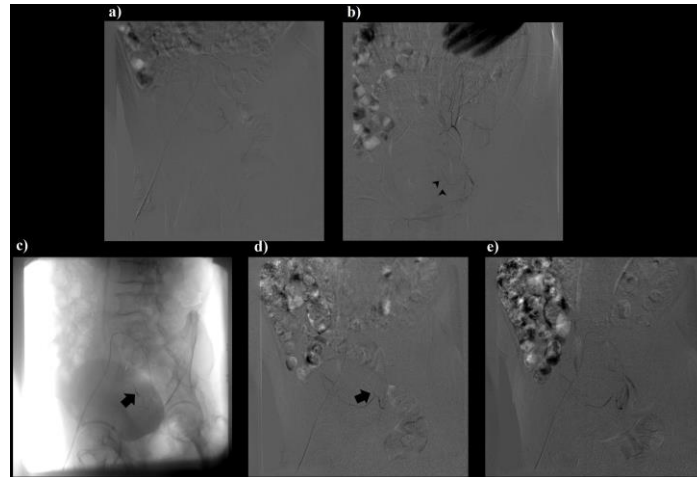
CT angiography and superselective catheterization of the left inferior epigastric artery showing the points of bleeding (arrowheads), the inserted hydrophilic coils (black arrows) and the progressive occlusion; a) and b) are pre-embolization; c), d) and e) are after embolization
